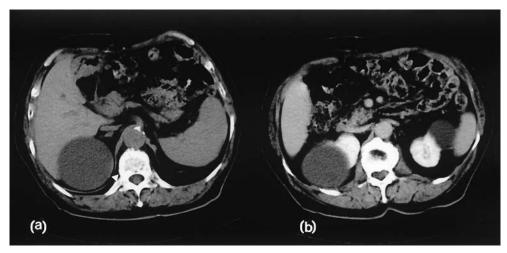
(a) Unenhanced CT showed a right cystic renal mass with minimal marginal calcification (arrowhead). (b) The right cystic renal mass was round and sharply marginated without evidence of enhancement after administration of contrast material.
